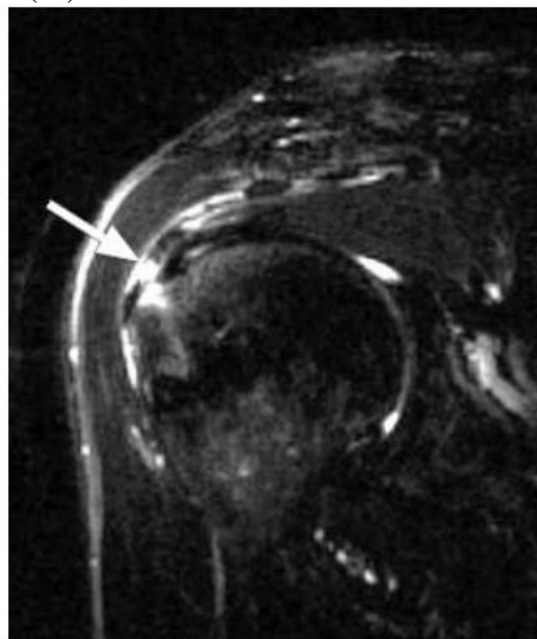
Coronal oblique fat-suppressed T2-weighted MR image shows partial tear of the supraspinatus tendon at bursal surface, outlined by fluid signal, denoting bursal surface partial thickness tear with bone marrow edema at the fibroosseous junction at the greater tuberosity (14)
